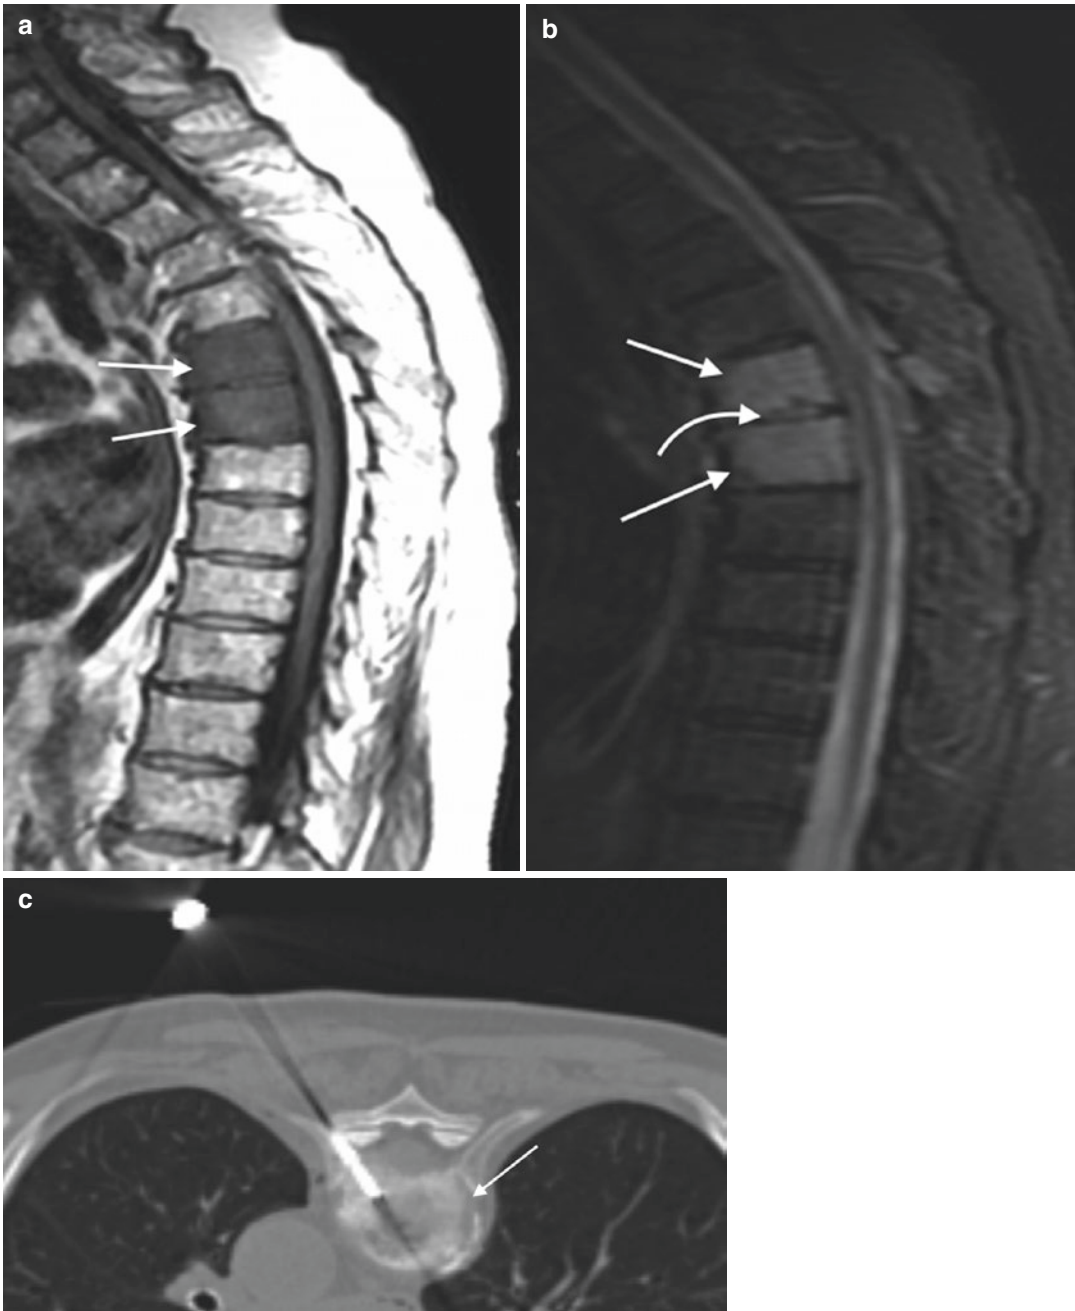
A 91-year-old female with remote history of pancreatic cancer presents with burning back pain. T1-weighted sagittal image (a) shows diffuse hypointense signal (arrows) within two adjacent vertebral bodies. The STIR sagittal image (b) shows hyperintense signal within the vertebral bodies (arrows) and the intervening disk
